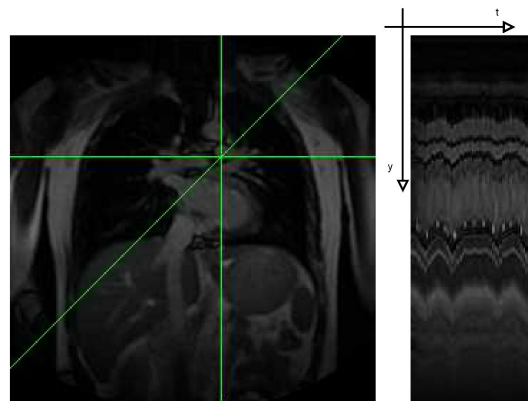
Example of MR image of the chest and a 2D vertical spatio-temporal (2DST) image.
